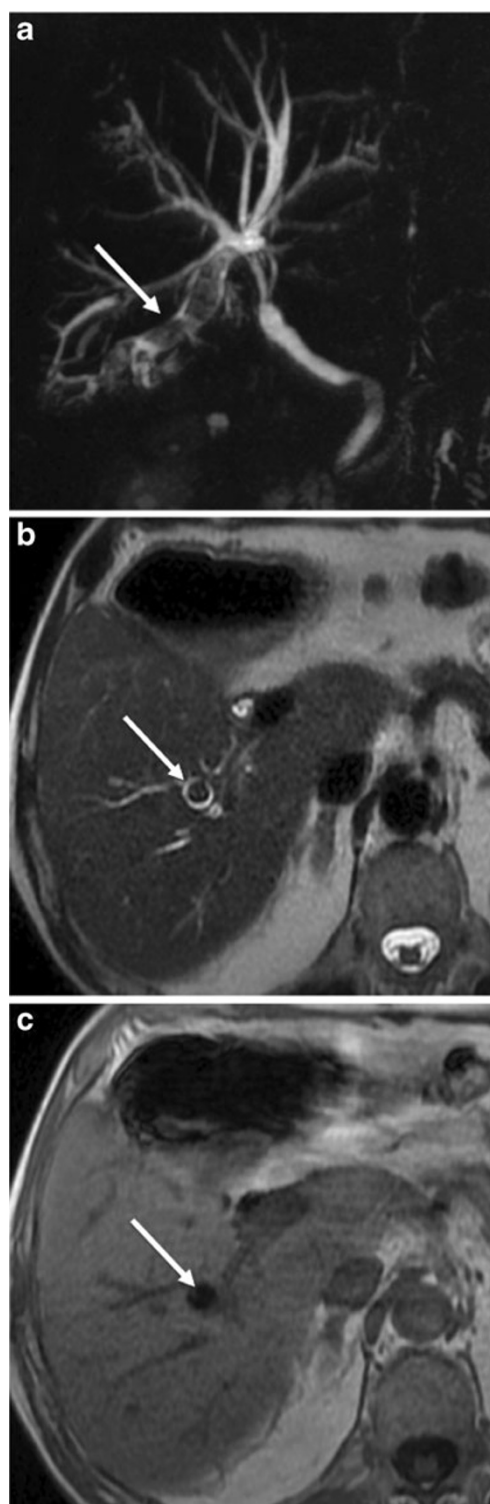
Segmental dilatation of segment VI bile duct filled with several stones in a 69-year-old man with LPAC syndrome. Coronal maximum intensity projection MCRP (a), transverse T2-weighted acquisition (b), and transverse in-phase T1-weighted acquisition (c) show a dilatation of segment VI bile ducts filled with several stones (*white arrow* in a). The stones appear as endoluminal signal voids on T2-weighted acquisition (*white arrow* in b) and hypointensities on T1-weighted acquisitions (*white arrow* in c)
